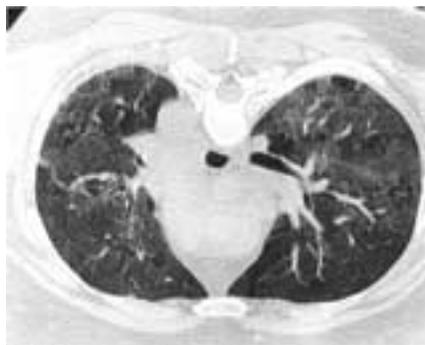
High resolution computed tomogram of the patient's chest shows "ground glass opacities" bilaterally, a finding suggestive of an active inflammatory process in the lung tissue.
